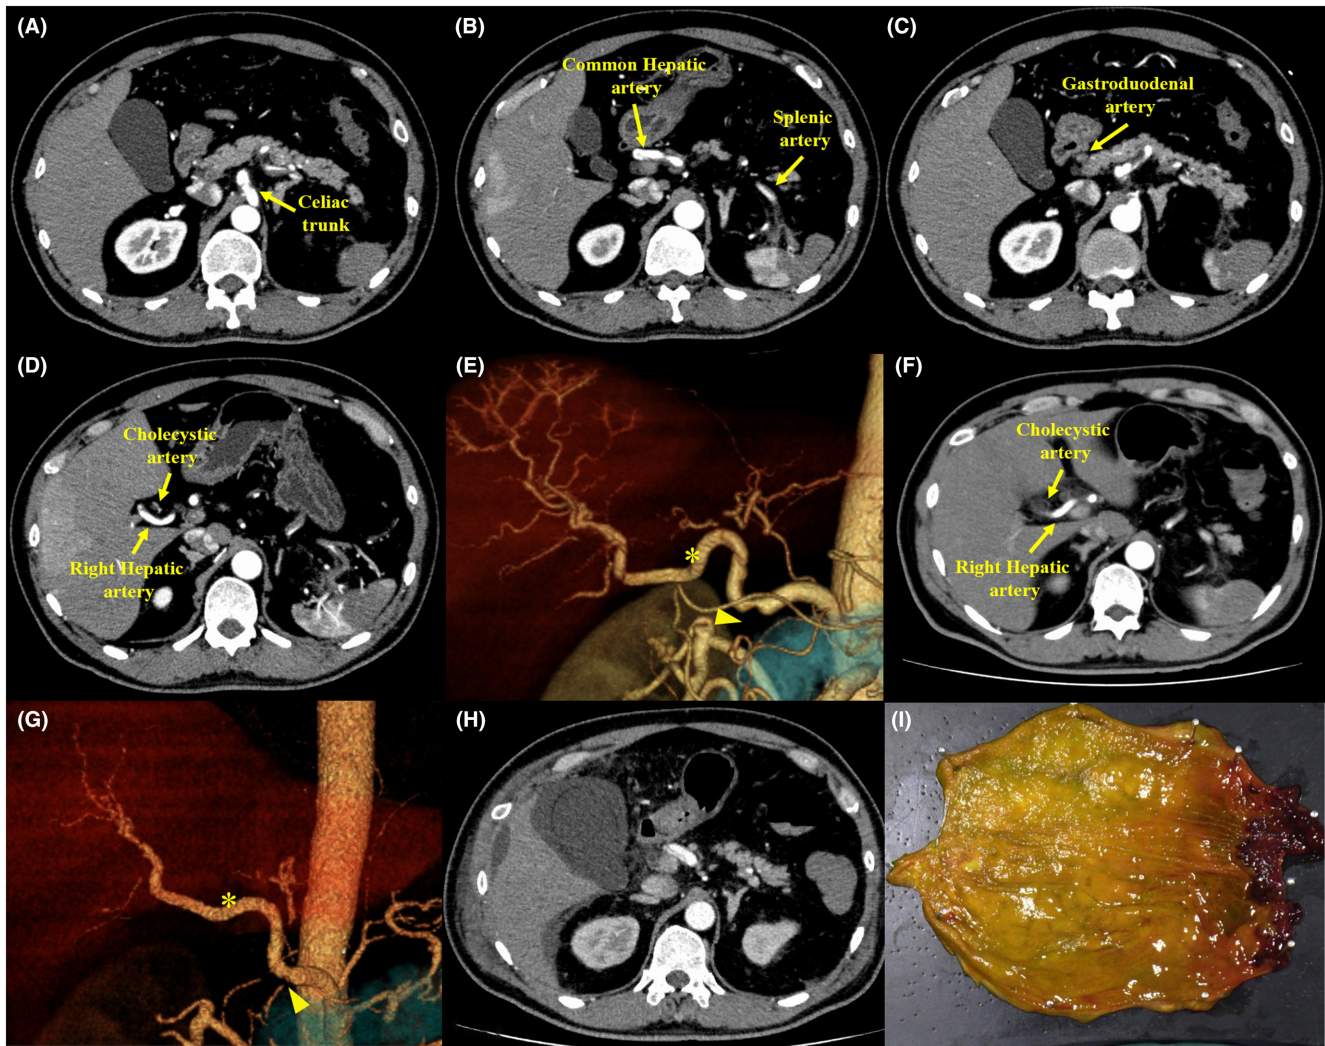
(A–D) Contrast-enhanced abdominal computed tomography (CT) scan on admission of a 50-year-old man with isolated celiac artery dissection. The scan shows extensive dissection from the celiac trunk to the splenic, common hepatic, and gastroduodenal arteries, with reduced spleen enhancement. The right hepatic artery and cholecystic artery remain patent. (E) 3D reconstruction of the aorta and branch vessels on admission displaying major patent branches originating from the right hepatic artery (asterisk) and poor opacification of the gastroduodenal artery at the confluence of the common hepatic artery (arrowhead). (F) Contrast-enhanced abdominal CT scan on day 3 revealing a loss of the enhancement effects of the cholecystic artery, whereas the right hepatic artery with progression dissection remains patent. (G) 3D reconstruction of the aorta and branch vessels on day 5 showing poor opacification of major branches from the right hepatic artery (asterisk) and poor opacification of the gastroduodenal artery (arrowhead), indicating compromised blood flow in the right hepatic artery due to the progression of dissection and insufficient collateral circulation through the gastroduodenal artery. (H) Axial image of contrast-enhanced CT on day 5 showing poor gallbladder wall opacification with pericholecystic fluid collection. (I) Pathological examination results revealing extensive gallbladder wall necrosis with marked softening and fragility, confirming ischemic change.
